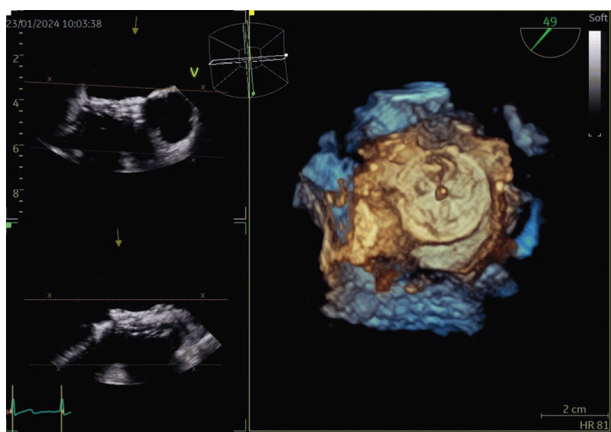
Intraoperative transesophageal echocardiography images show the device positioning in triplane
